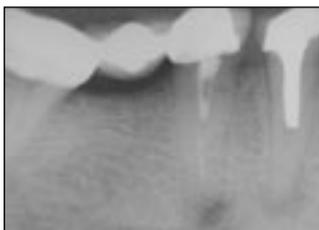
Periapical radiograph showing tooth 44 and 45. There was no root filling present apical to the post in 44 and inadequate root filling present in tooth 45. There were periapical radiolucencies associated with both teeth.
